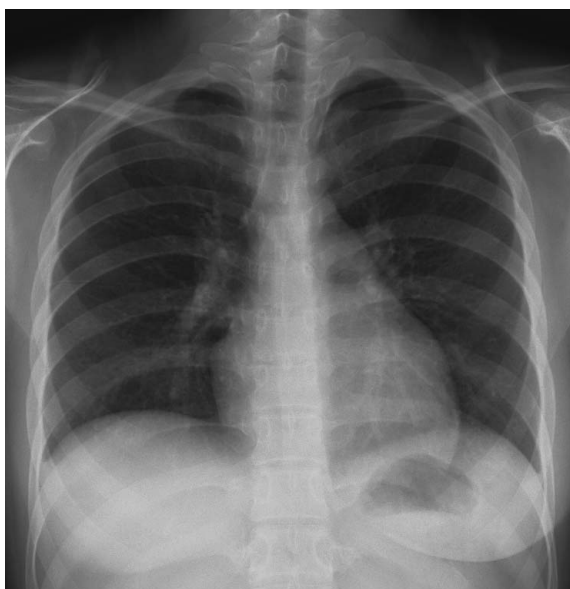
A chest X-ray on admission. A chest X-ray revealed bilateral reticular shadows and ground glass opacities in both lower lung fields.
